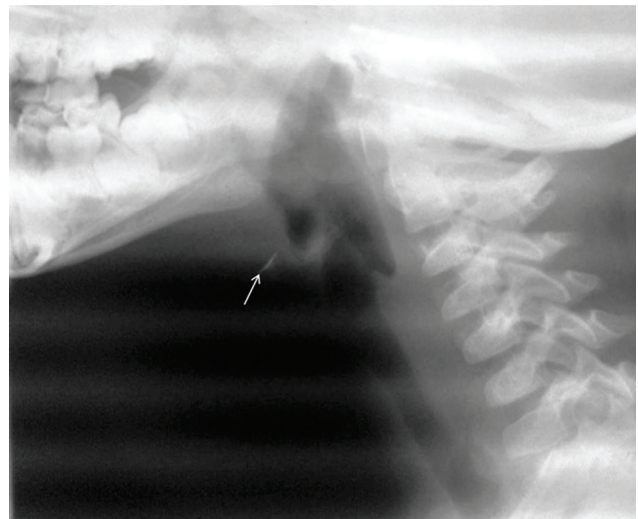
X-ray of neck soft tissue showing the plastic foreign body (arrow) after the X-ray thinning (washed).
